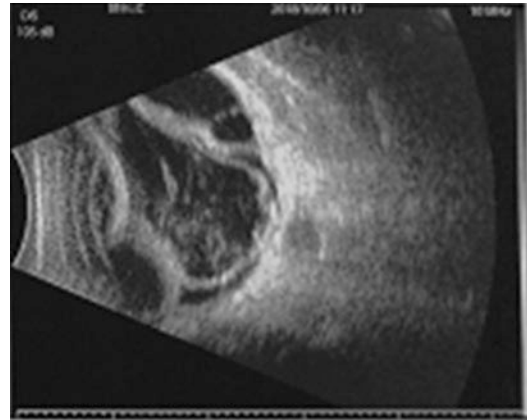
Choroidal detachment with retinal detachment in B-scan ultrasonography. By courtesy of professor Hua Yan from Tianjin Medical University, China
